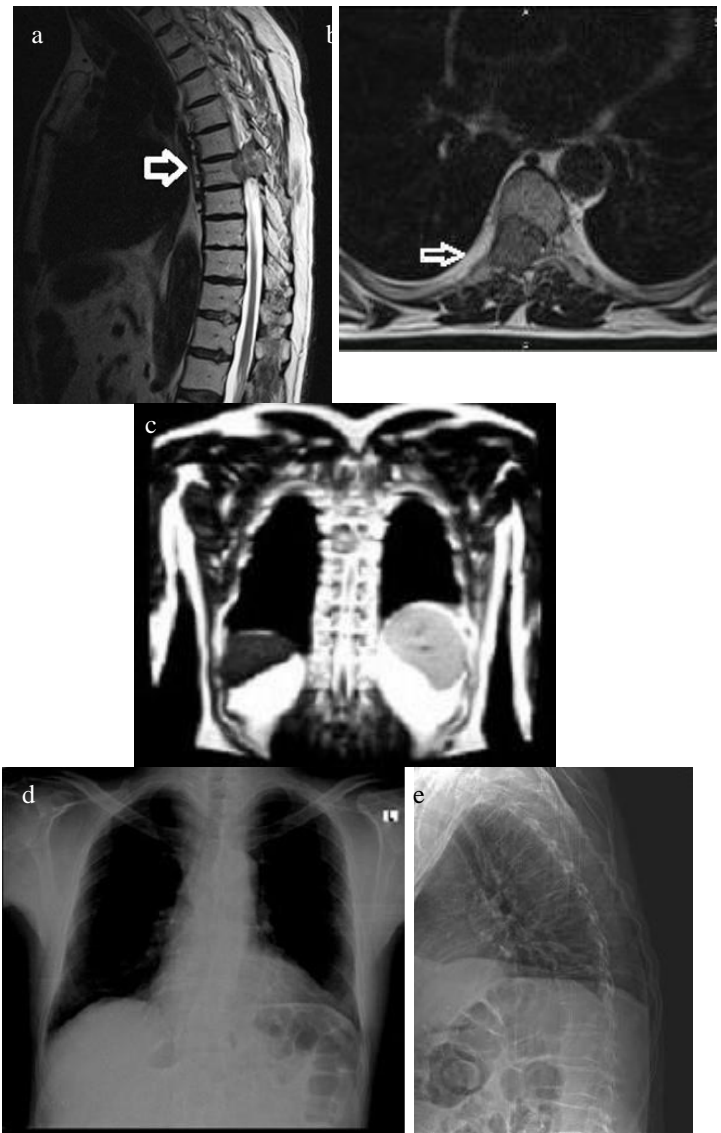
Preoperative sagittal views of T1-weighted (a), axial (b), and coronal (c) magnetic resonance images. Anteroposterior (d) and lateral (e) X-rays show the T7 metastasis (arrow)
